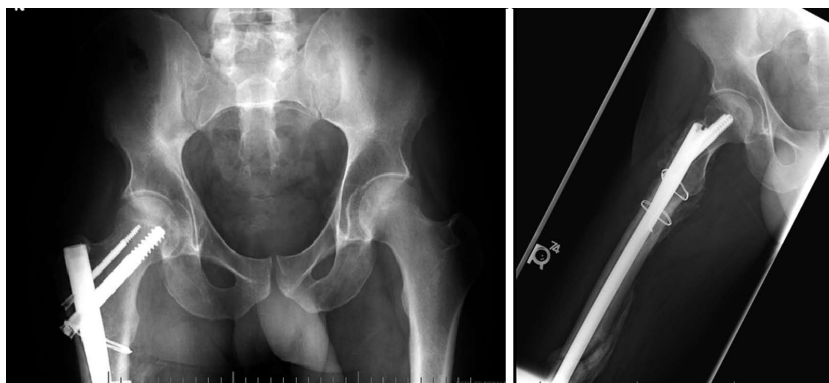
Anteroposterior and lateral radiographs six months after internal fixation of the peri-implant fracture.
